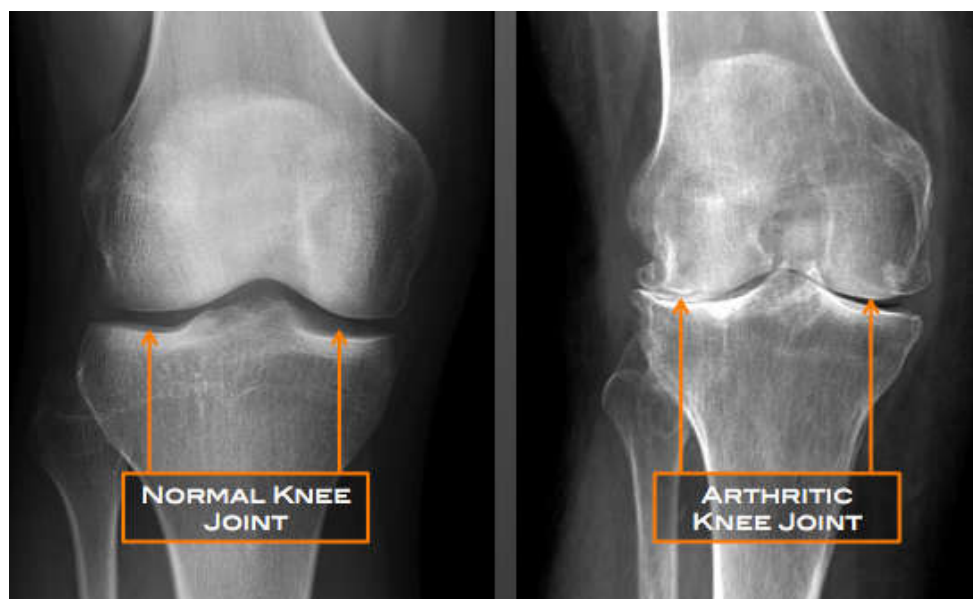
X-ray of normal and arthritic knee (IMPAX, Agfa HealthCare Corporation, Greenville, SC, USA)
